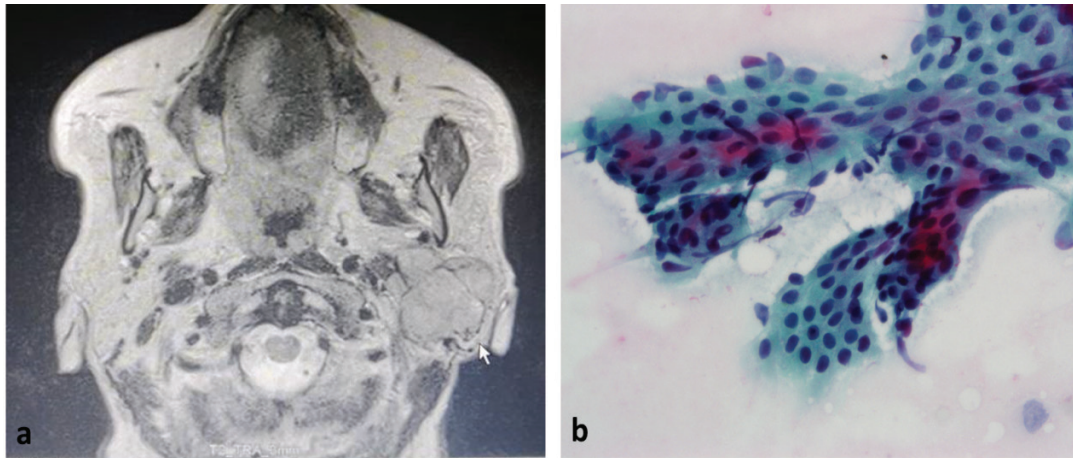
(A) MRI revealed a left parotid mass (arrow) involving the deep lobe. (B) FNA of the mass showed monolayered clusters of uniform oncocytes exhibiting round nuclei within granular cytoplasm, low nuclear: cytoplasmic ratio and no significant atypia (cervical smear, x600).
